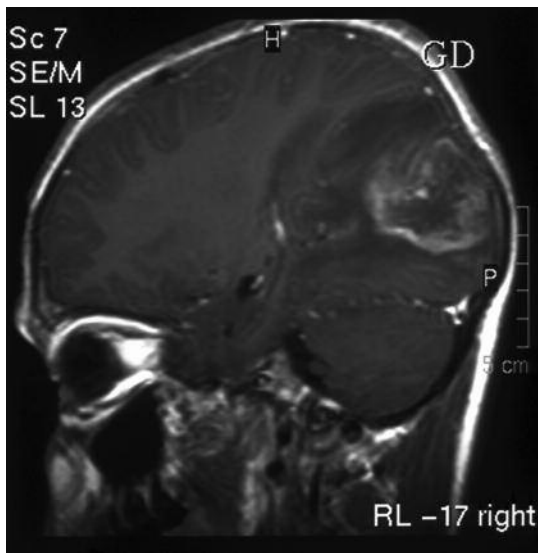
An enhanced lesion in the right occipitoparietal lobe by magnetic resonance imaging (MRI).
